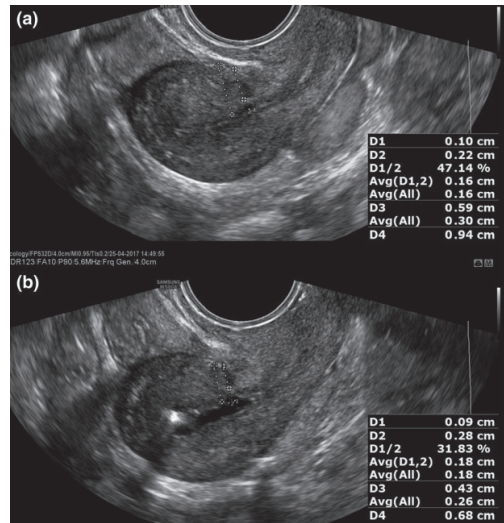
Both transvaginal ultrasonography (a) and sonohysterography (b) showing concordant results for a small isthmocele. D1, depth of isthmocele; D2, width of isthmocele; D3, thickness of residual myometrium; D4, thickness of adjacent myometrium. [Color figure can be viewed at wileyonlinelibrary.com]
